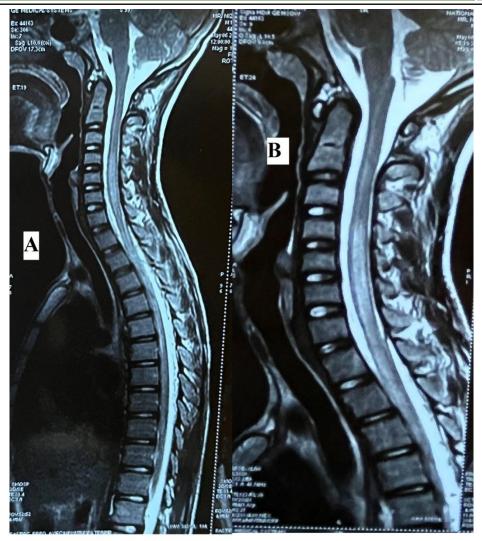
A and B are T2-weighted sagittal section of spinal cord
